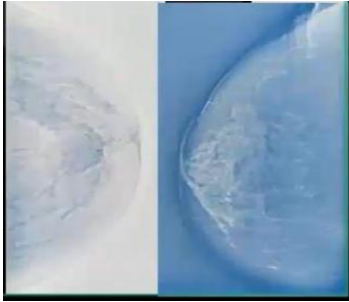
Xero Radiography
